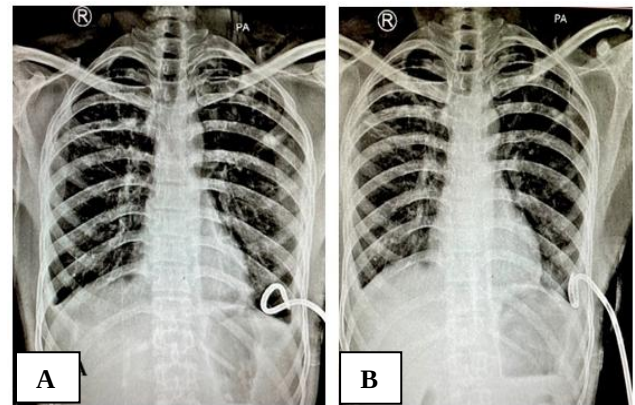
Chest x-rays showing Pigtail catheter in the left sided loculated pleural effusion- (A) on day 1 and (B) on day 8 showing complete drainage of left sided pleural effusion on day 8.
